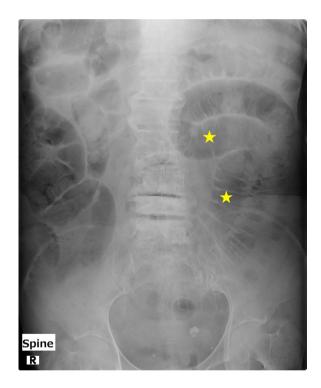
Abdominal radiography demonstrating dilated small bowel (star)
